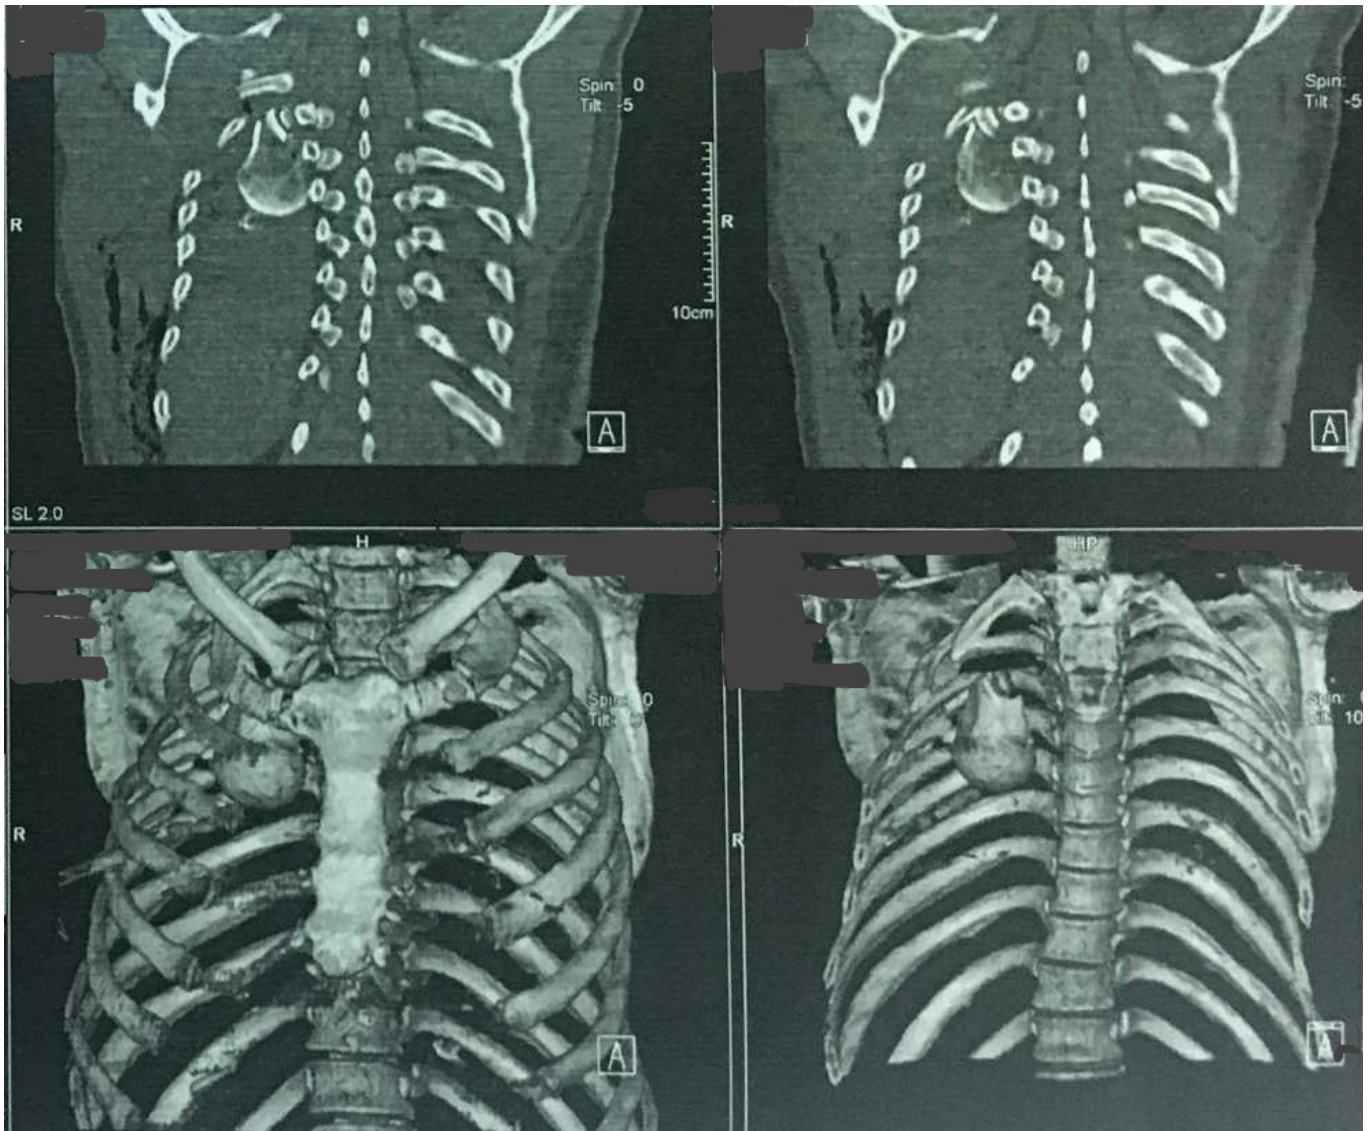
The spiral computed tomography of chest with 3-Dimensional reconstruction. Head of humerus in right hemithorax.
